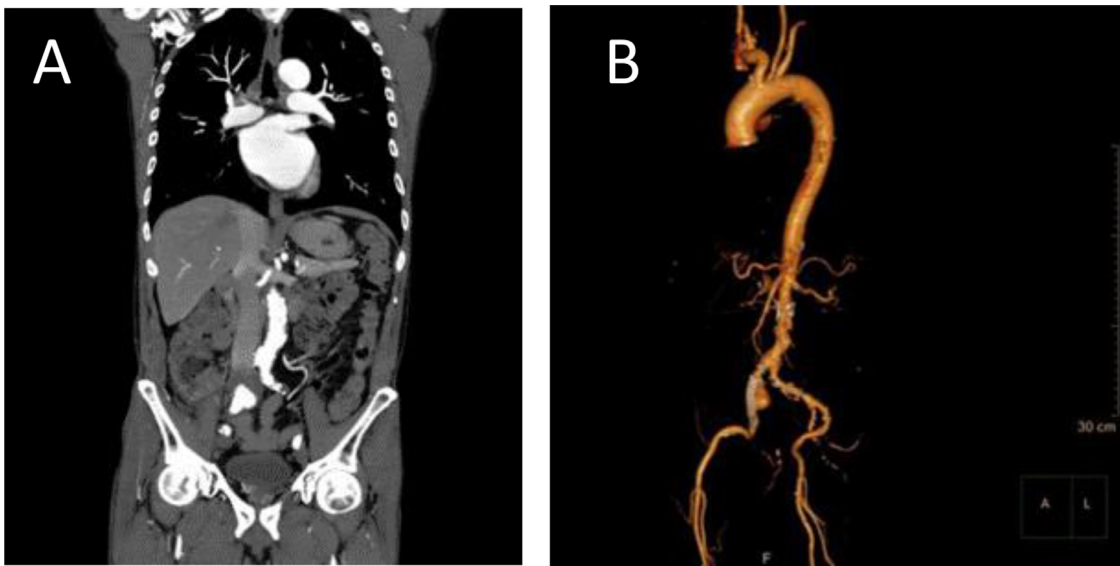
On the fourth day after the operation,CTA shows that the right common iliac aneurysm, iliac vein, and inferior vena cava were poorly opacified, suggesting type II endoleak with an arteriovenous fistula.
